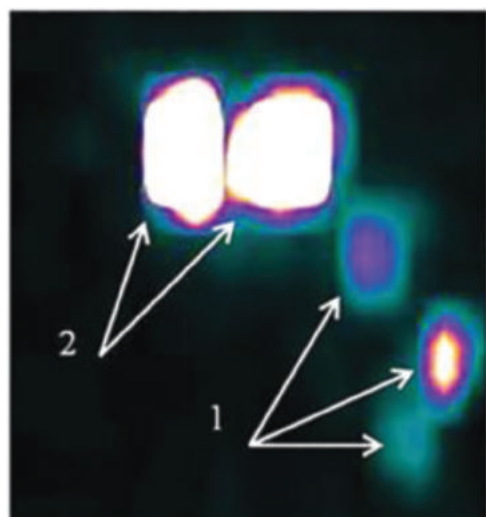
SPECT image of a patient with laryngeal cancer: 1 – radiopharmaceutical uptake in the projection of the lymph nodes of the neck on the left ( $n = 3$ ); 2 – injection site
